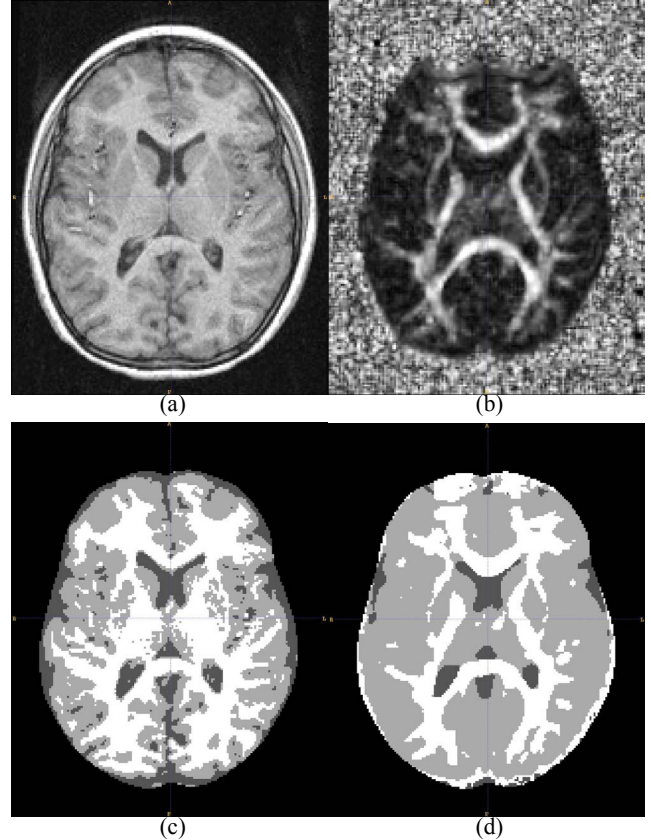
Axial slices showing *subcortical* regions in the: (a) MR image, (b) FA image, (c) segmentation using the MR image alone, and (d) segmentation using the orthogonal tensor invariants alone.
